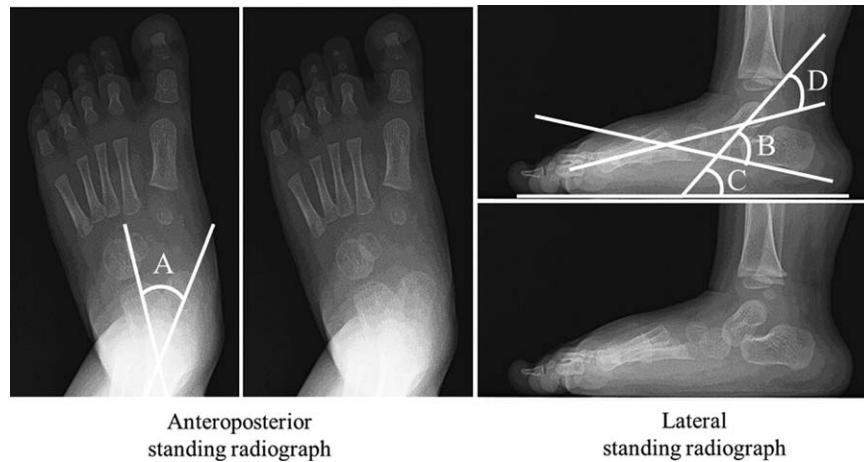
Flatfoot indicators on standing radiograph: anteroposterior talo-calcaneal angle (A), lateral talo-calcaneal angle (B), talus-sole-of-foot angle (C), and talo-first metatarsal angle (D).
